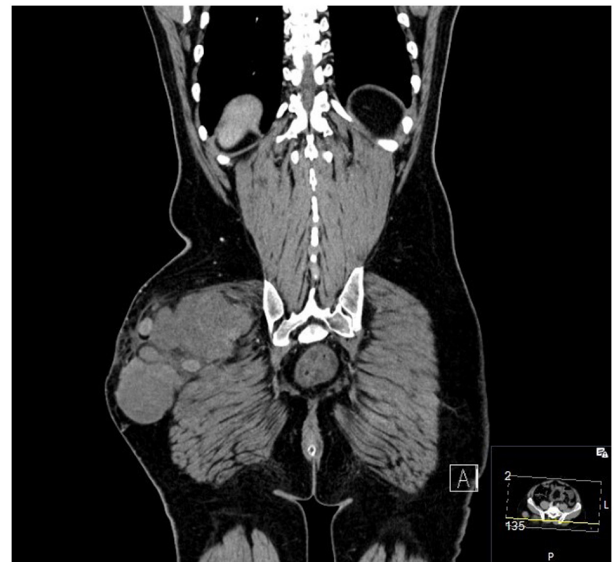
CT coronal view of the tumor (2012). CT, computed tomography.
